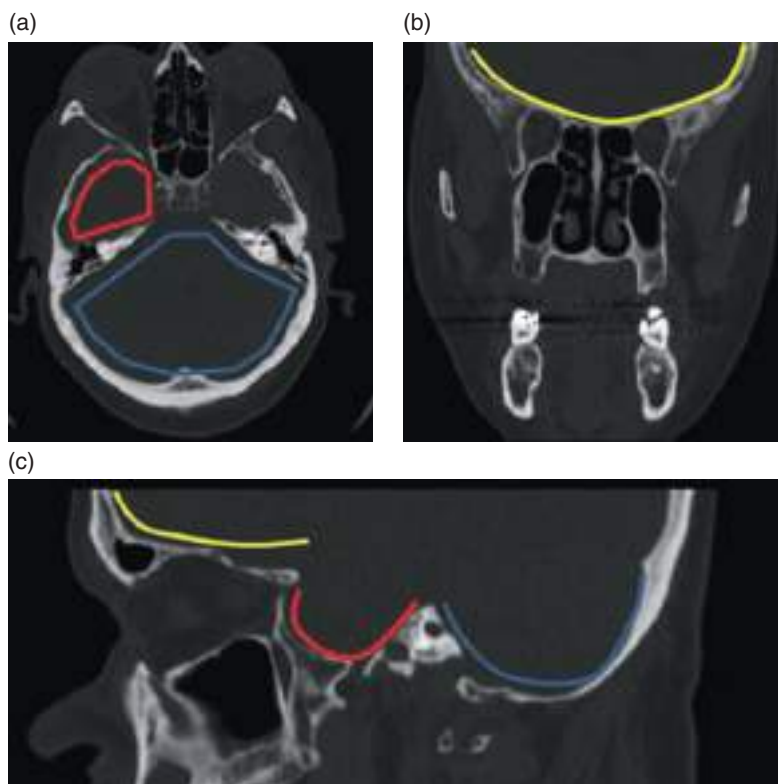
Bone anatomy of the cranial fossae. (a) Axial CT image. (b) Coronal CT multiplanar reconstruction (MPR) image. (c) Sagittal MPR CT image. Yellow, anterior cranial fossa; red, middle cranial fossa; blue, posterior cranial fossa.
